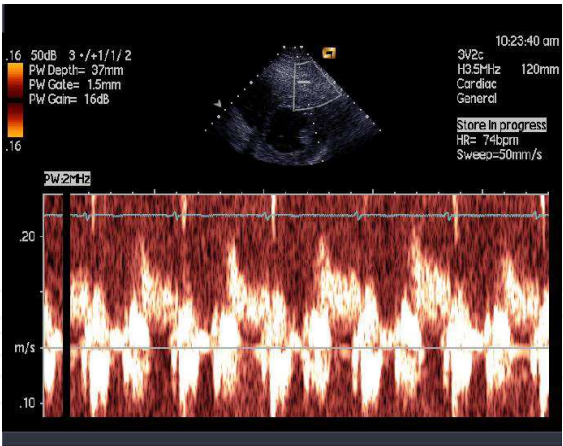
Consistent pulsed-wave Doppler sampling of LAD blood velocity
